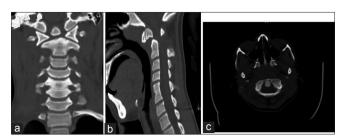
(a and b) Coronal and sagittal reformat computed tomography (CT) of upper cervical spine showing Os odontoideum and backward displacement of the C2 vertebral body. (C) Bone window axial view of C1 and C2 CT scan showing narrowing of the space between C1 and C2
